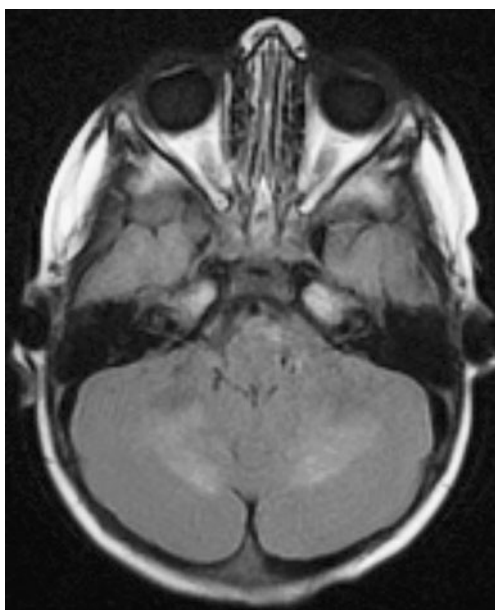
Axial T2-W FLAIR MR image shows T2 signal prolongation within the corpus medullaris of the cerebellum
